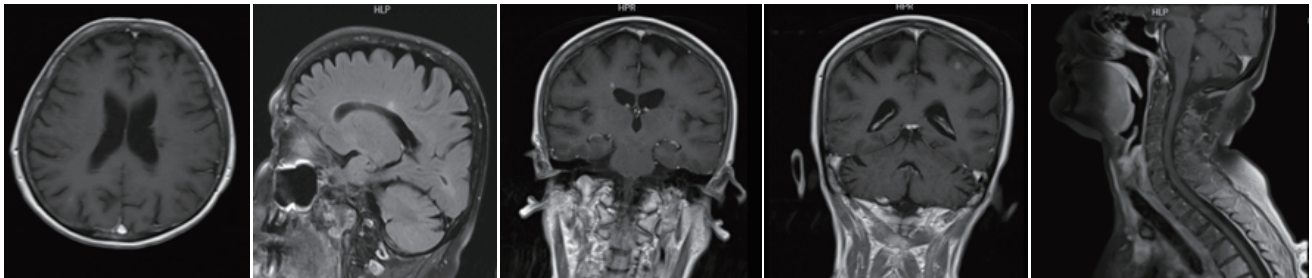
In the control contrast brain and cervical MRI taken 1 year later in Case 2, a lesion with contrast uptake on the right disappeared whereas two punctual contrast uptake continue
